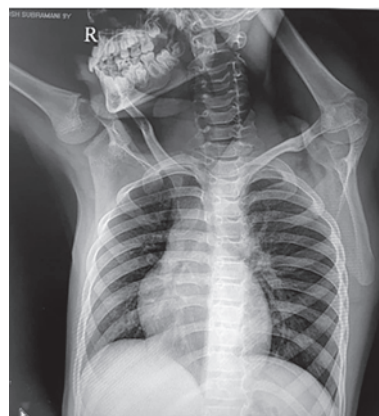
Chest X-Ray: Rotated to right side
